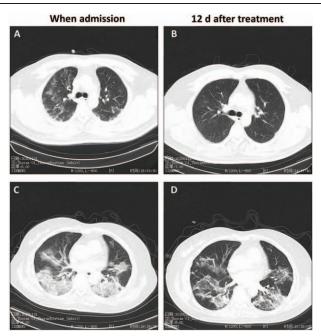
CT scan for a 36-year-old male moderate patient when admitted (A) and 12 days after treatment (B). And CT scan for a 61-year-old female severe patient when admitted (C) and 12 days after treatment (D). In (A) and (C), clear and obvious ground glass lesions could be seen when admission. After treatment, the ground glass lesions of both patients obviously decreased.
